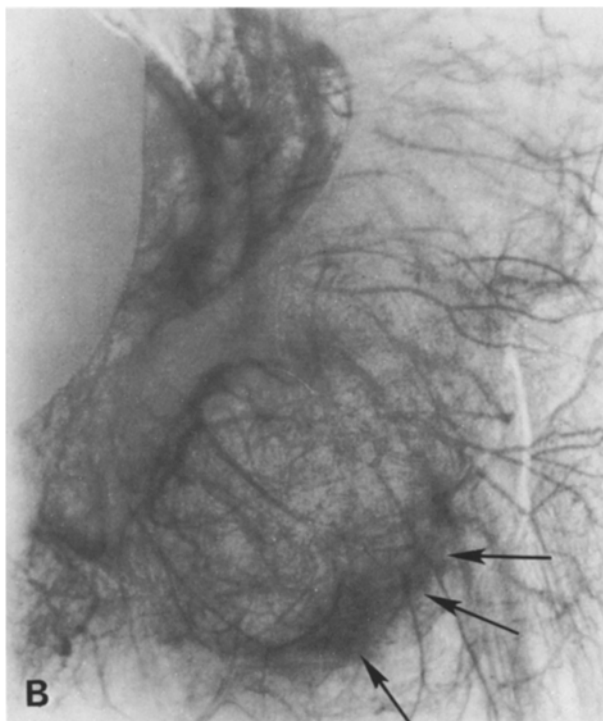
Recurrent aneurysmal bone cyst in 15-year-old male. A Initial plain film examination demonstrates expansion of ischium with no visible matrix. B Selective iliac arteriogram reveals only moderate vascularity but an area of capillary blush (arrows) more intense than the rest of the lesion is seen in the lower lateral aspect. C Twelve months later progressive destruction of bone chips with further expansion indicates recurrence (arrows). Recurrence was identified first in the area of vascularity
